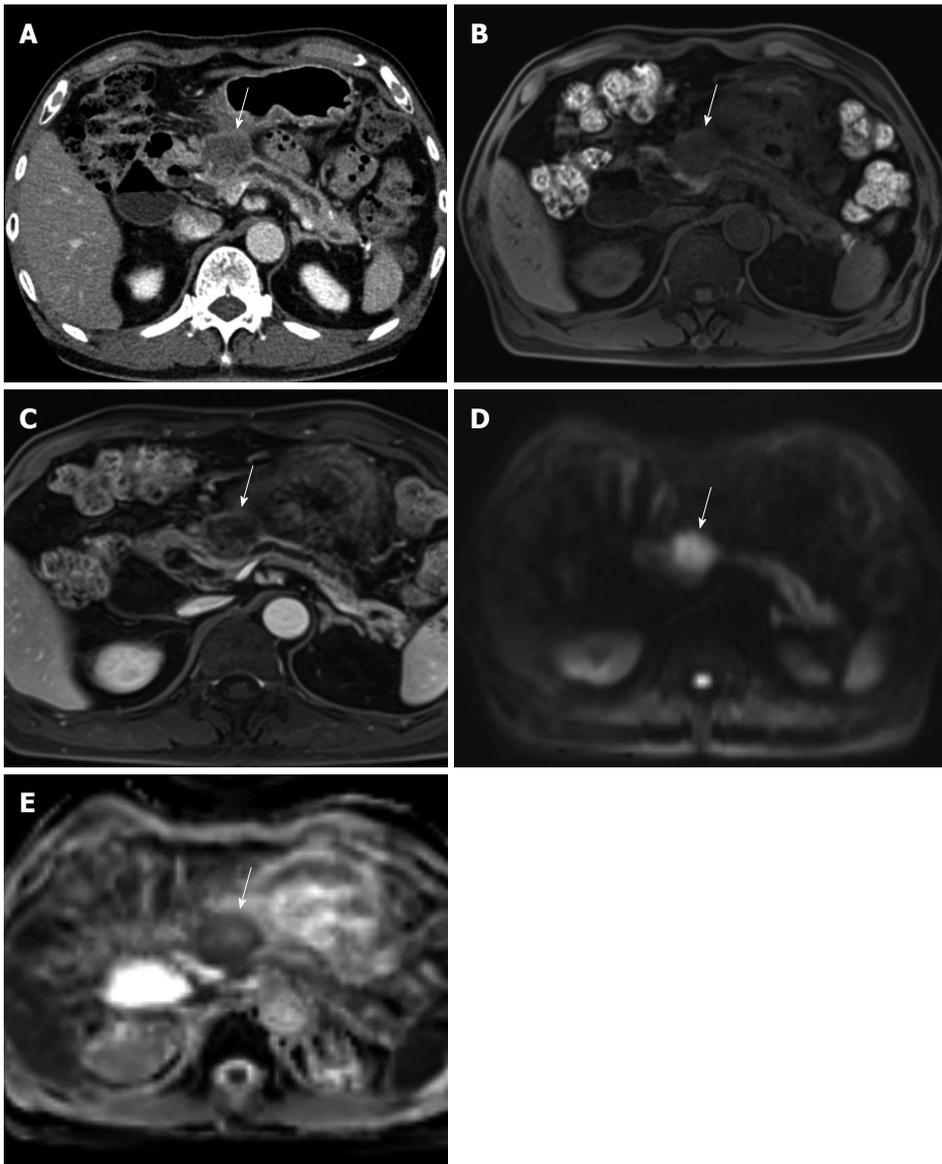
A 73-year-old male with pathologically-proven pancreatic head cancer. A: Approximately 3 cm low attenuating mass (arrow) is noted at the pancreatic head on the CT scan; B: In pre-contrast T1-weighted gradient echo sequence of MR, this mass (arrow) shows lower signal intensity, compared to the normal pancreatic parenchyma; C: After contrast media administration, the pancreatic head cancer (arrow) has poor enhancement; D, E: DWI with 1000 of b-value and ADC map reveal the diffusion restriction of the pancreatic head cancer (arrow). CT: Computed tomography; MR: Magnetic resonance; DWI: Diffusion weighted imaging; ADC: Apparent diffusion coefficient.
